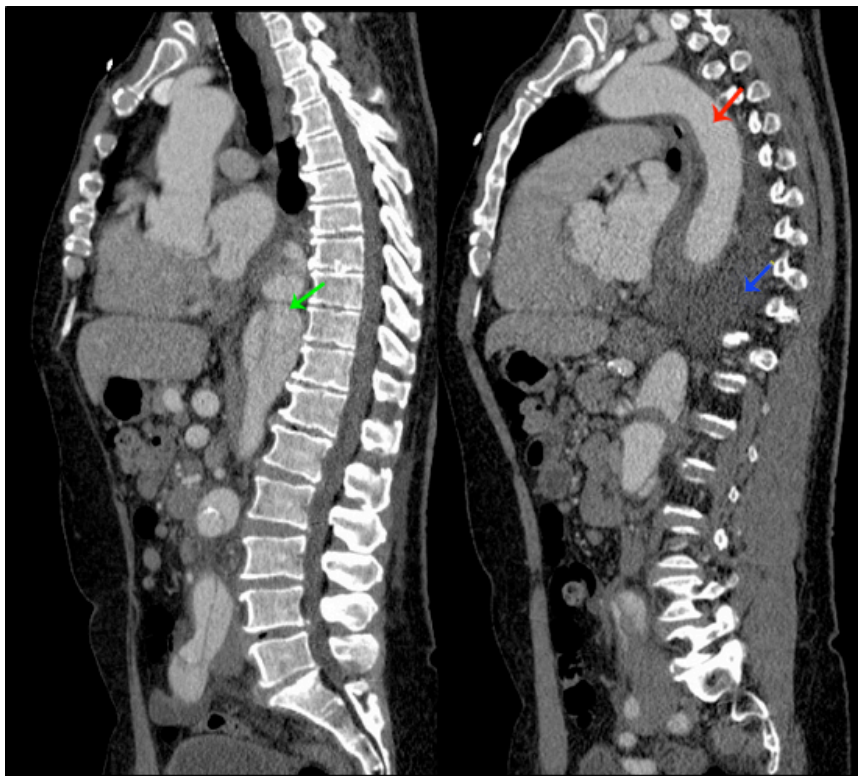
PATIENT 1. ACUTE TBAD IMAGES FROM CT SCANS AT PRESENTATION. BLUE ARROW INDICATES THROMBUS FORMATION. RED ARROW INDICATES THE POSITION OF THE TRUE LUMEN. GREEN ARROW INDICATES LOCATION OF INTIMAL TEAR.
